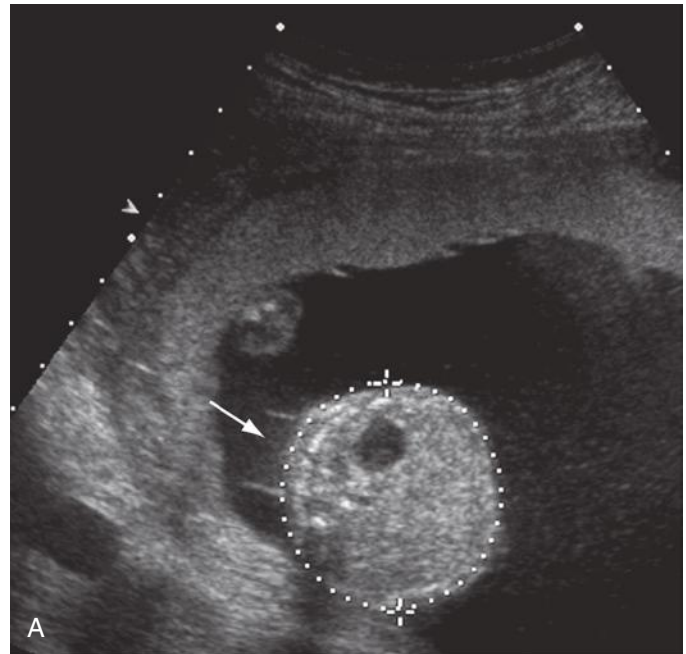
A, Sonogram of the fetal abdomen and surrounding amniotic fluid in a case of twin-to-twin transfusion syndrome. At first glance the fluid surrounding the donor abdomen appears to reside within its amniotic sac. In fact, there is only a small amount of hyperechogenic fluid (*arrow*) seen within the amniotic sac that enshrouds the fetus. B, Sonogram of the two amniotic sacs in a pregnancy with twin-to-twin transfusion syndrome. The amniotic fluid (*arrow*) surrounding the donor twin (Do) is more echogenic than the fluid in the recipient sac (Re).
